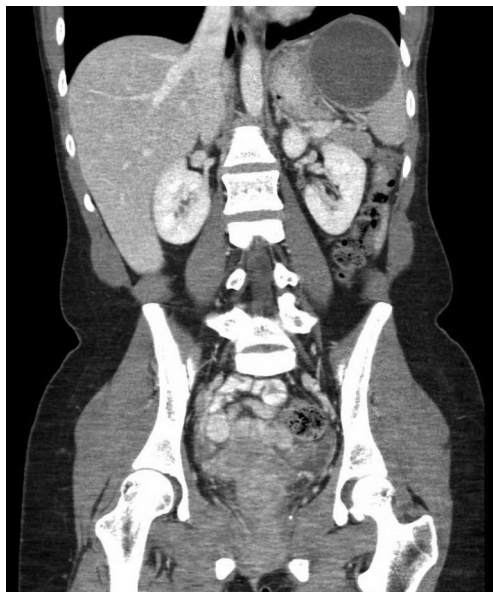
Coronal slice of a CT scan (venous phase) of the abdomen demonstrating a cyst (7.2×8 cm) in the upper pole of the spleen.
